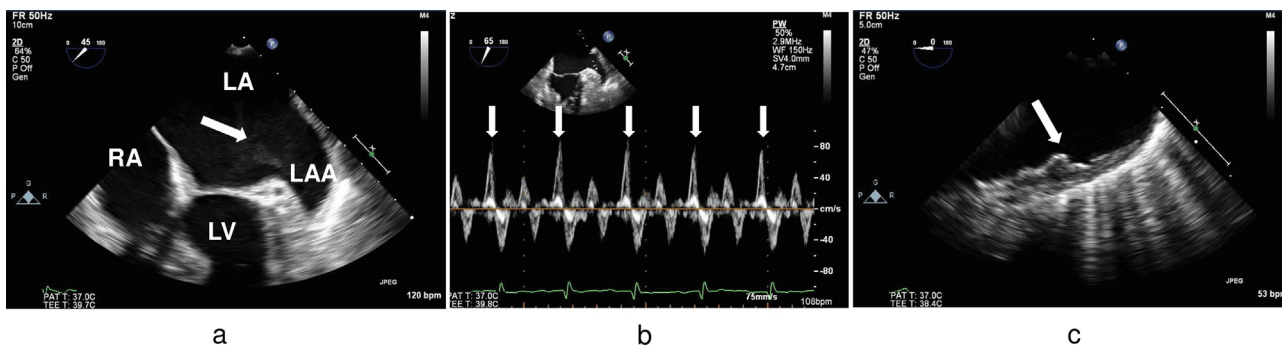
Example images of transesophageal echocardiography. a spontaneous echo contrast in the left atrium (arrow). b pulsed-wave Doppler recording showed left atrial appendage emptying velocity of 79 cm/s (arrow). c a large atherosclerotic plaque (arrow) in the aortic arch. LA, left atrium; LAA, left atrial appendage; LV, left ventricle; RA, right atrium; SEC, spontaneous echo contrast.
